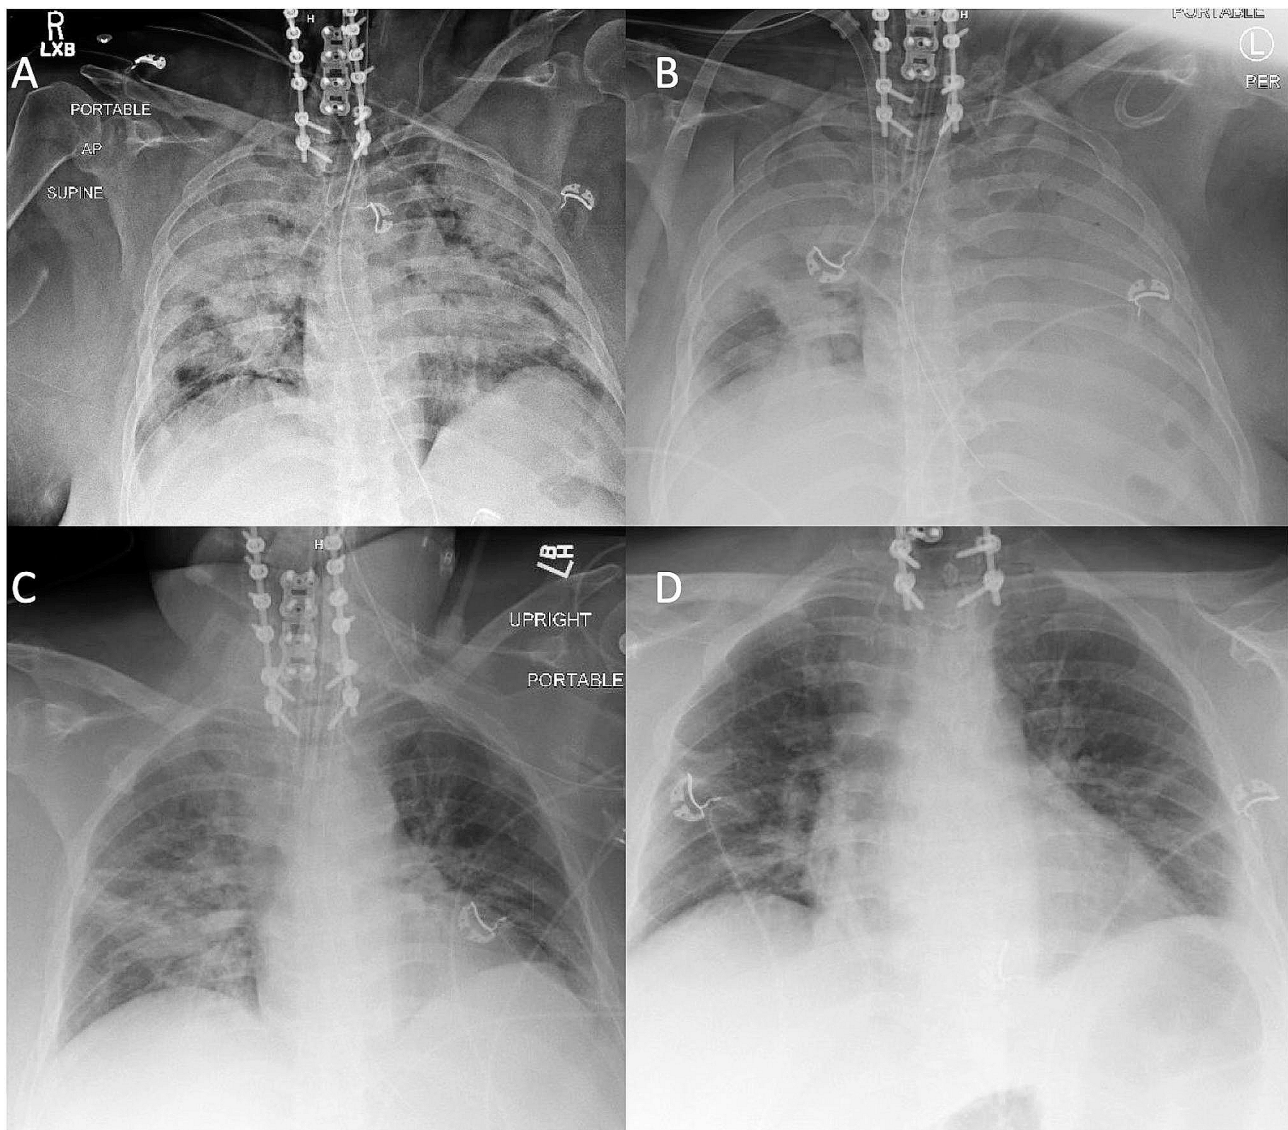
Chest x-ray on hospital day 1 after intubation and cardiac arrest. B) Chest x-ray on hospital day 1 after VV-ECMO cannulation. C) Chest x-ray on hospital day 8 after VV-ECMO decannulation. D) Chest x-ray on hospital day 11 after extubation
